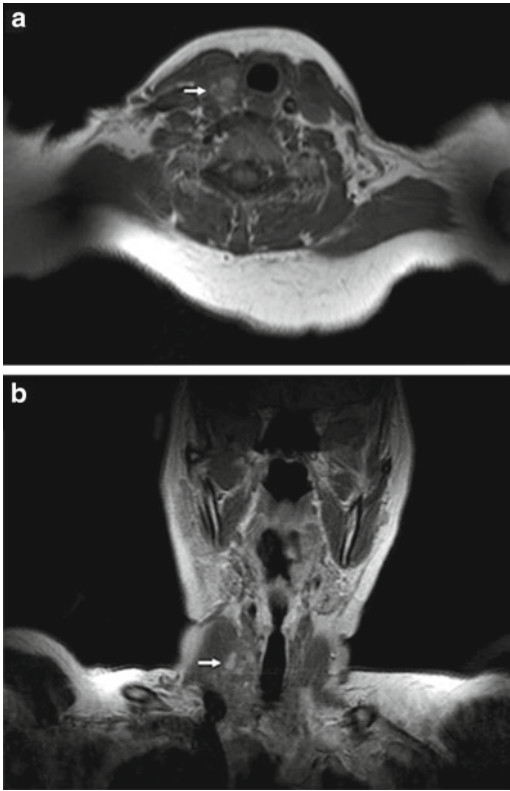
Parathyroid adenoma. Gadolinium-enhanced T1-weighted MRI demonstrates an enhancing lesion (arrow) along the inferoposterior aspect of the right thyroid lobe on (a) transverse and (b) coronal tomograms. The left thyroid lobe is surgically absent. Later, a parathyroid adenoma was surgically resected from this site
